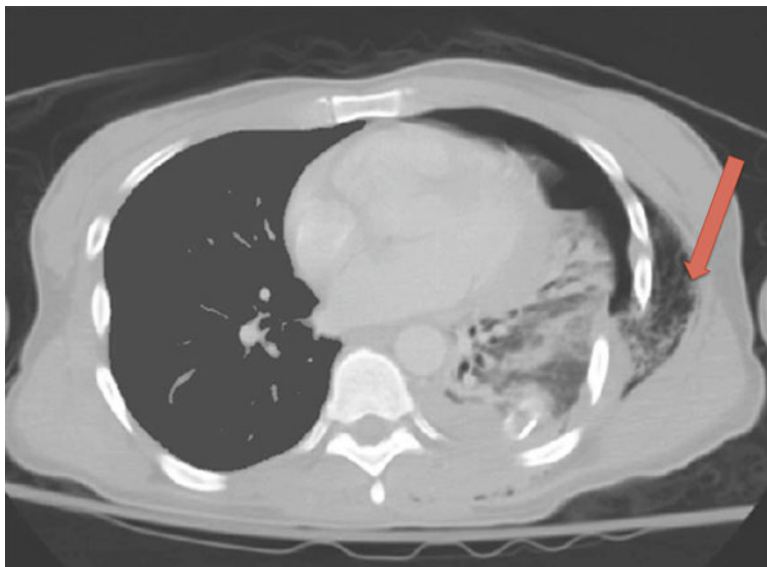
Another operative indication is seen on this CT scan that demonstrates lung tissue (*red arrow*) outside the chest wall. Again, lung herniation of this nature represents
